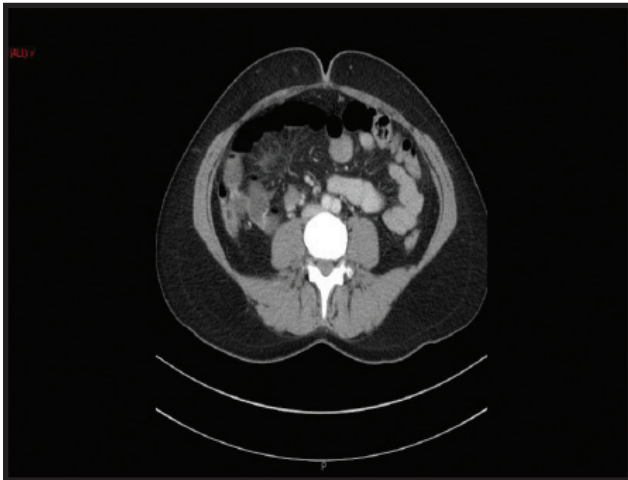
CT scan showing terminal ileum thickening.
